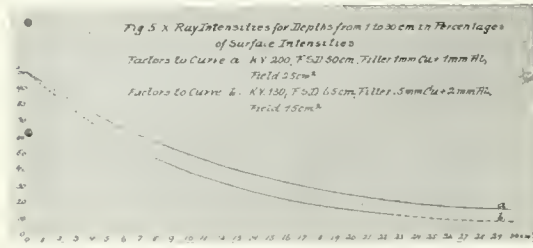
X-ray intensity graphs with the chief factors.
